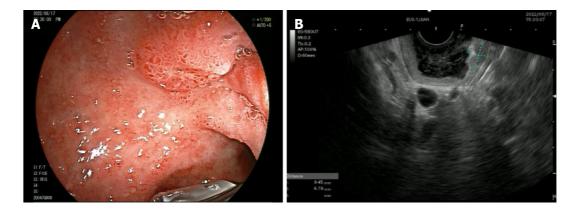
Imaging of lesions in the duodenal bulb via ultrasound endoscopy. A: Ultrasound endoscopy revealed a hypoechoic focus in the duodenal bulb that was irregularly shaped; B: The lesion originated from the submucosa.
